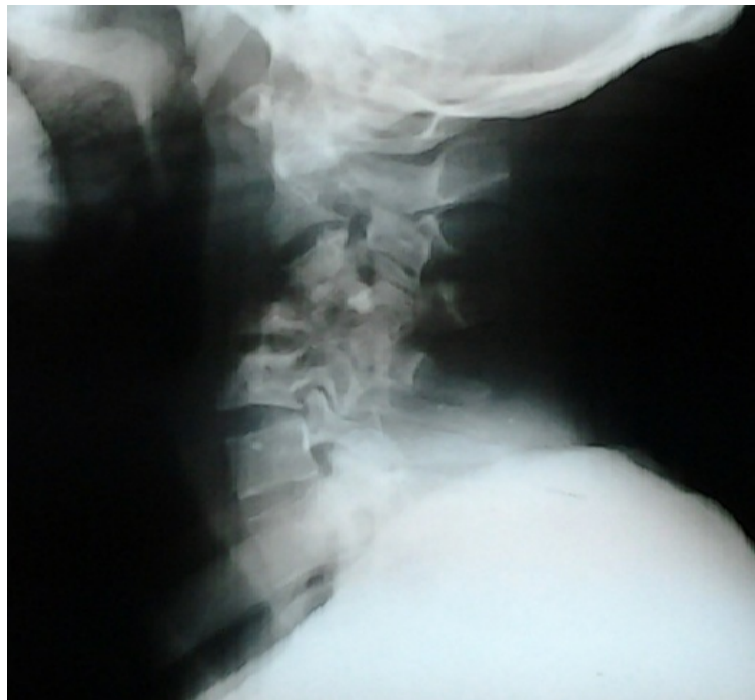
Plain cervical spine X-ray of the patient showing collapsed vertebral bodies of C3 to C5 with destruction of their intervening discs, and segmental kyphosis.
